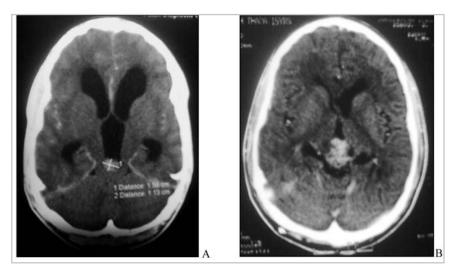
Plain Computed tomography (CT) scans. A) An enhancing mass in pineal region and secondary dilatation of the ventricular system. B) Post V-P shunt, well defined mixed density predominately hyperdense lesion in pineal region located at the posterior aspect of the 3rd ventricle.
